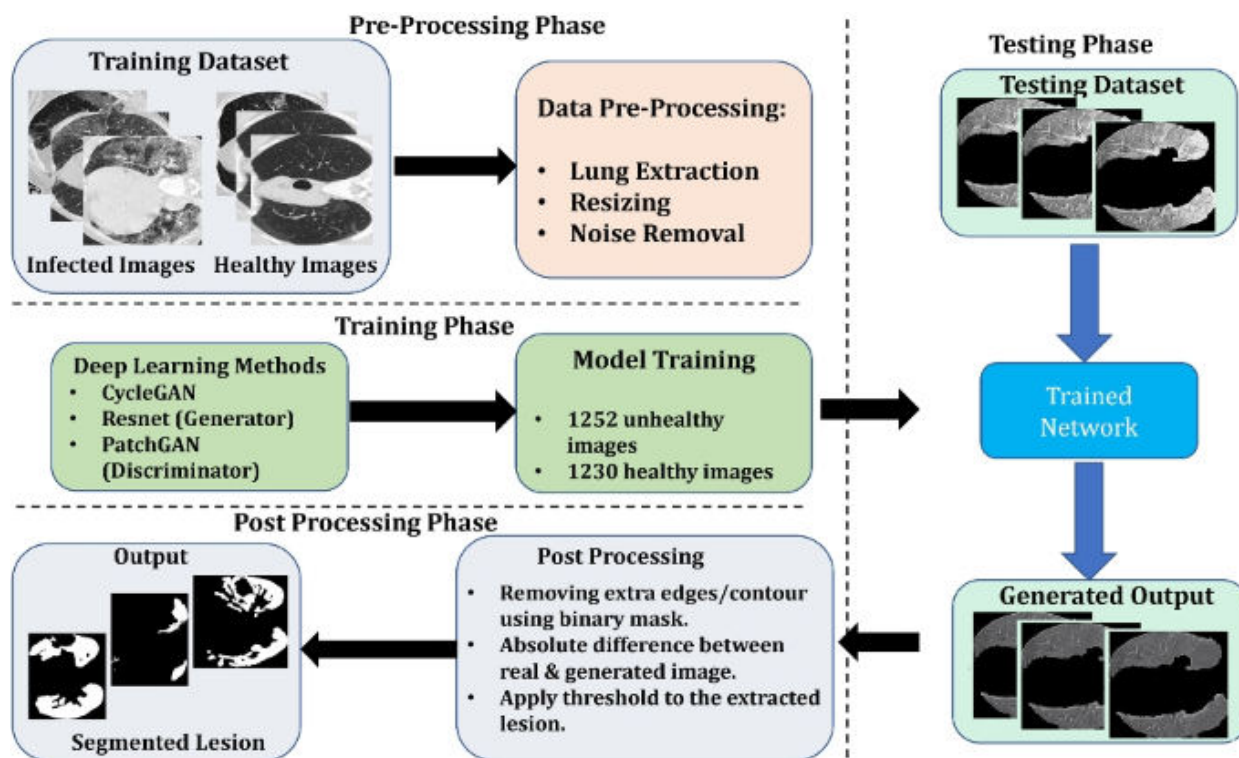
Lesion segmentation in lung CT scans
